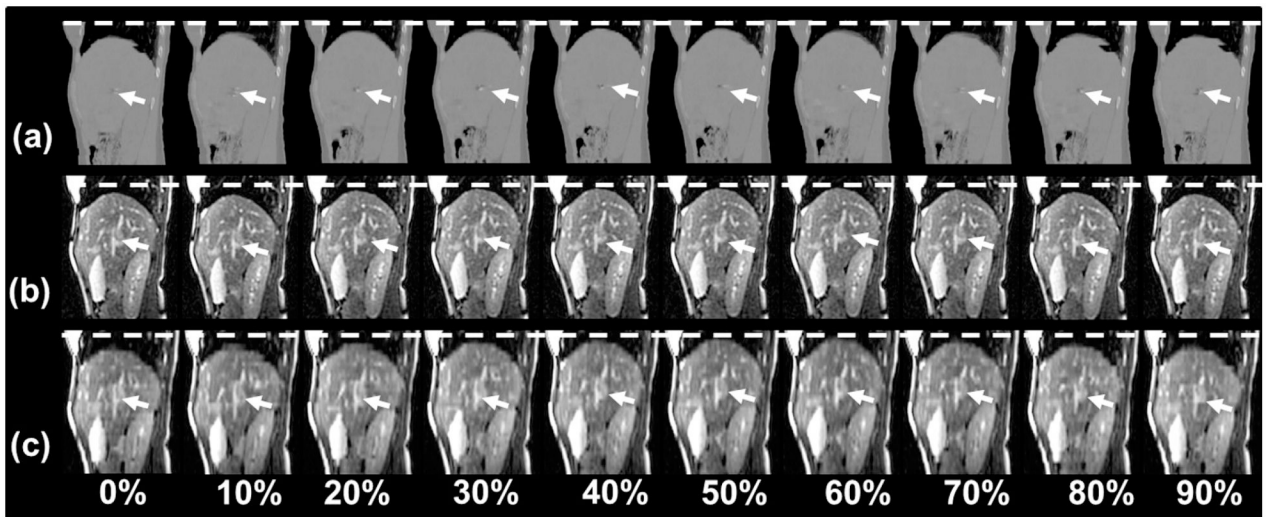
Representative sagittal 4-dimensional (4D) computed tomography (a), 4D magnetic resonance imaging (MRI) (b), and cine-MRI (c) for a liver cancer patient. White dashed lines are drawn to facilitate the visualization of the respiratory motion. Arrows indicate the tumor. Although the tumor (indicted by arrows) is nearly invisible in the 4D computed tomography images, it can be readily seen in both the cine-MRI and 4D-MRI images.
